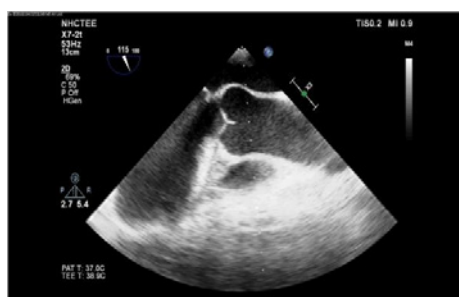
TOE image-parasternal long axis view.
